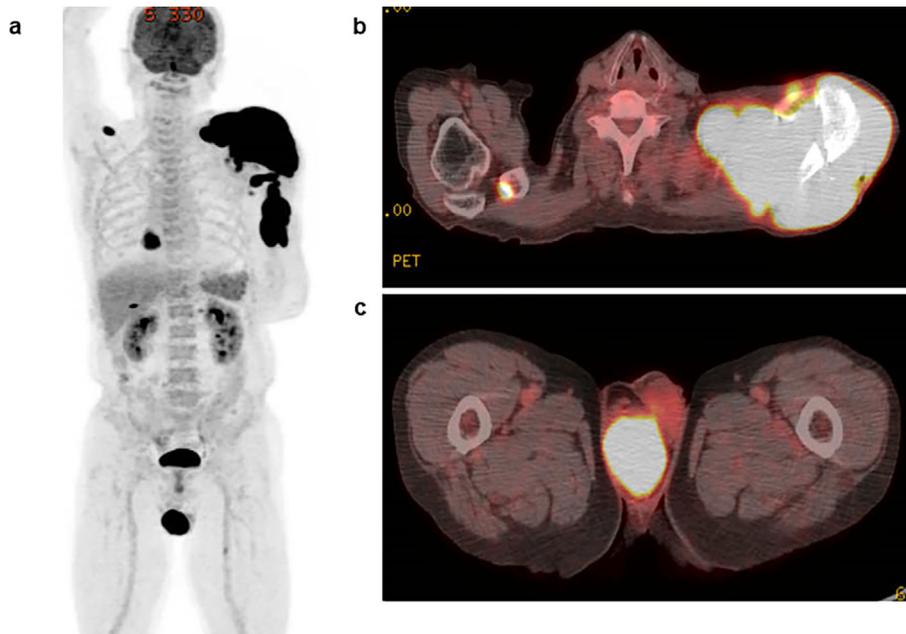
Radiological findings at the diagnosis. (a) ^{18}F -fluoro-2-deoxy-D-glucose-positron emission tomography (FDG-PET) of the whole body shows an increased glucose uptake in the left shoulder, involving the humerus, scapula, and surrounding soft tissue. Furthermore, the uptake of glucose is evident in the right testis and right mediastinal and axillary lymph nodes. The maximum standardized uptake value is 22.3. (b, c) Integrated FDG-PET/computed tomography shows an increased glucose uptake in the left shoulder (b) and right testis (c).
